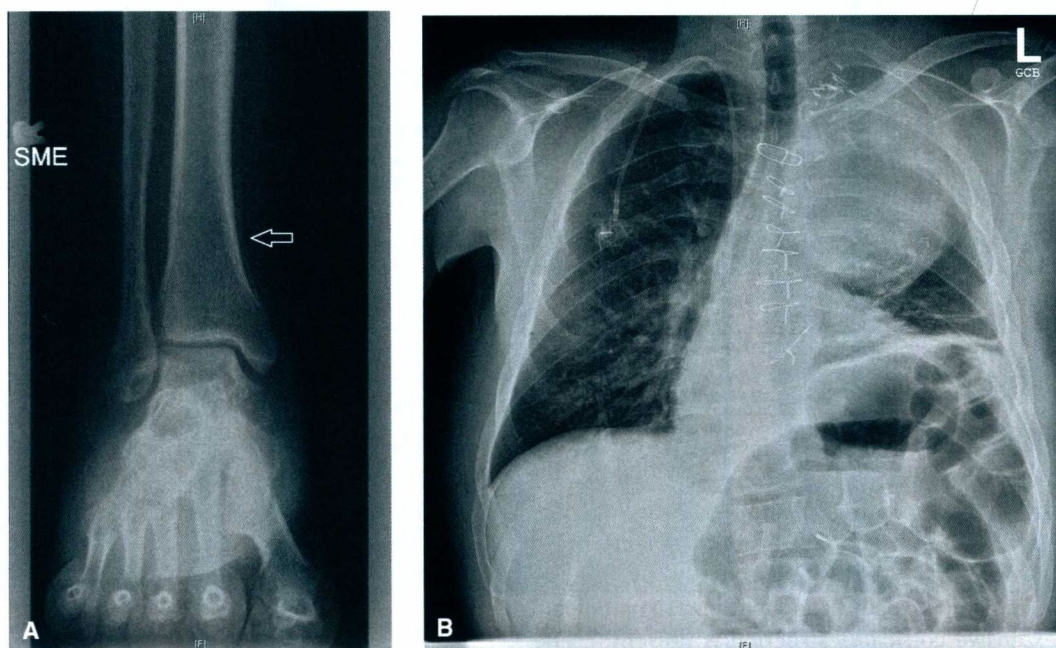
Radiographic presentation of HPO. A: X-ray of the right ankle demonstrates thick periosteal reaction at the distal aspect of the long bone, sparing the epiphysis (arrow) without underlying bone pathology. Posteroanterior (PA) radiograph of the chest (B) in the same patient demonstrates a large, left upper lobe lesion.
